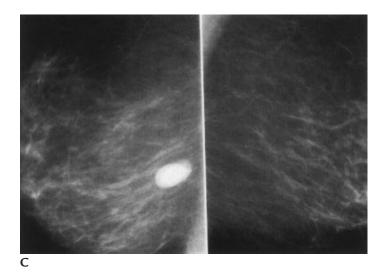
(*Continued*) (C) Left 90° lateromedial and mediolateral oblique (MLO) views back to back. Mass is seen on the 90° lateromedial view, but not the MLO. Medial lesions are best evaluated on lateromedial views because medial tissue is placed against the bucky. Solid mass on ultrasound (not shown). In the absence of prior film for comparison, this lesion can be followed (category 3, probably benign lesion; short-term follow-up is recommended.)
